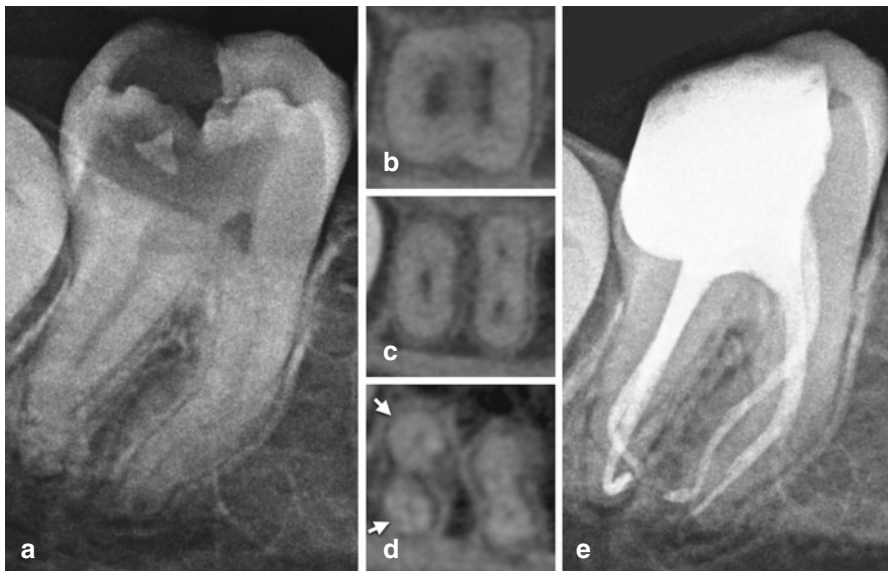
Preoperative periapical radiograph of a right mandibular second molar (a) with corresponding axial CBCT slices captured from the coronal third (b), mid-root (c), and apical third (d). The axial CBCT slices demonstrate two distinct mesial canals as well as a division of the distal root in the apical third (white arrows). The post-endodontic radiograph demonstrates all identified root canals treated (e)
